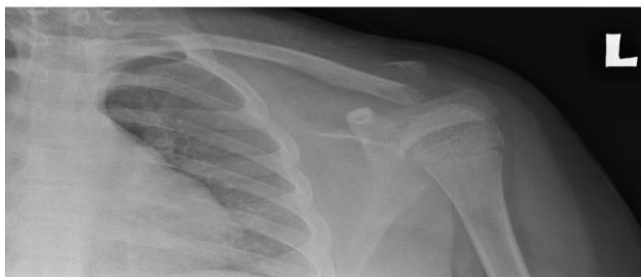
Xray Left Shoulder Pre-op
